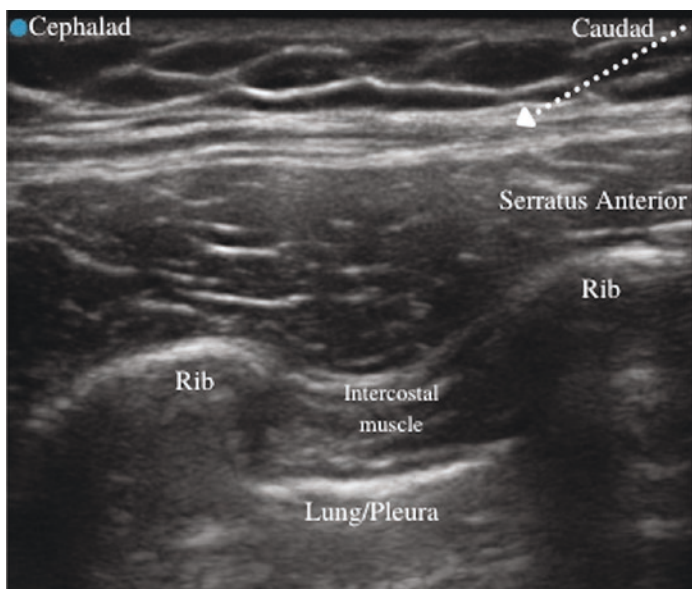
Ultrasound image of serratus anterior plane block. Dotted line represents needle trajectory with arrow pointing to site of local deposition
